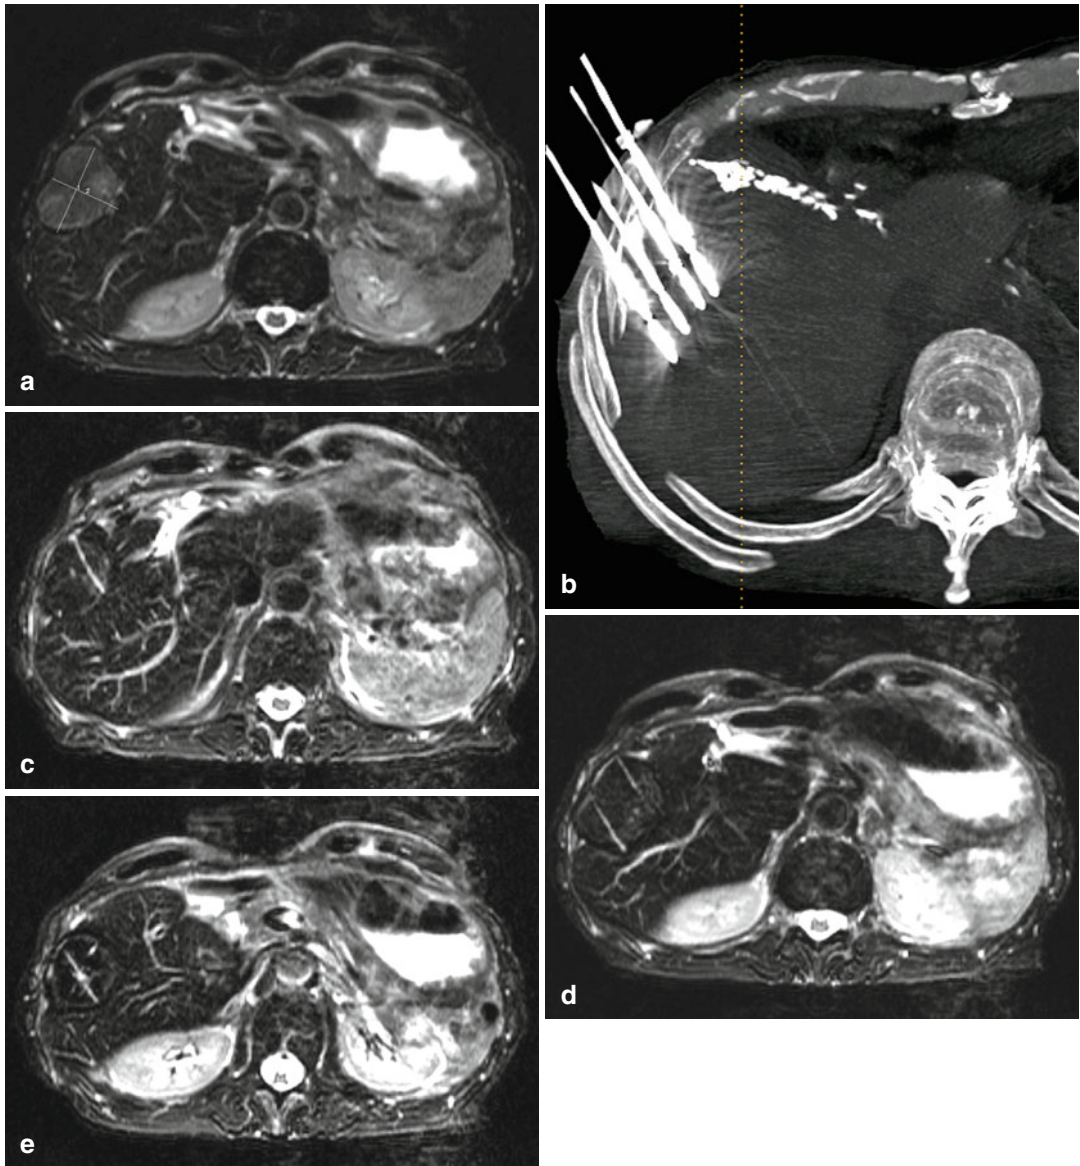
T2-weighted MR image of a 47×37-mm HCC in the remaining right liver after previous left hepatectomy (a). Thick slab MIP of the CT obtained after placement of 4 microwave antennae (b). Axial T2-weighted
